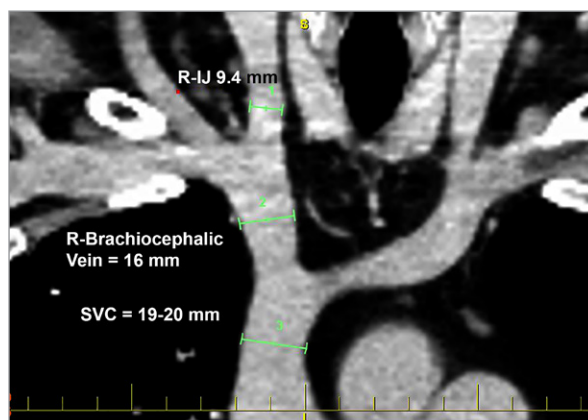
Computed tomographic angiogram of the chest shows these diameters: right internal jugular vein (R-IJ), 9.4 mm; right brachiocephalic vein, 16 mm; and superior vena cava (SVC), 19.5 mm.
